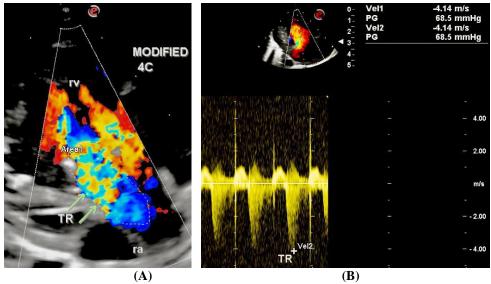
Tricuspid regurgitation. In the modified 4C view on color flow mapping a moderate tricuspid regurgitation jet was recognized. The jet area was 1.40 sqcm. On continuous flow doppler analysis tricuspid regurgitation jet velocity was 4.11 m/sec (peak gradient 68 mmHg). TR, tricuspid regurgitation; RV, right ventricle; ra, right atrium.
